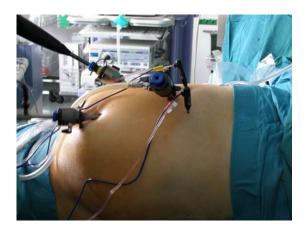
Surgery – exploratory laparoscopy / sonography with RFA
